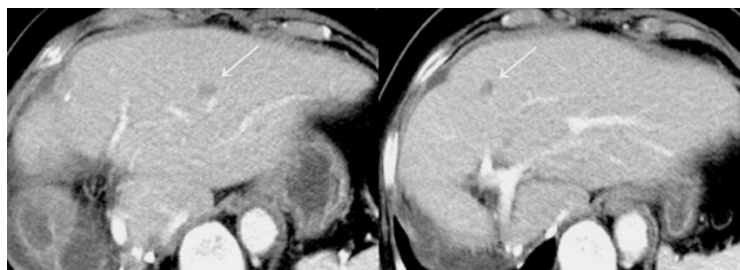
CT image showing liver metastasis
